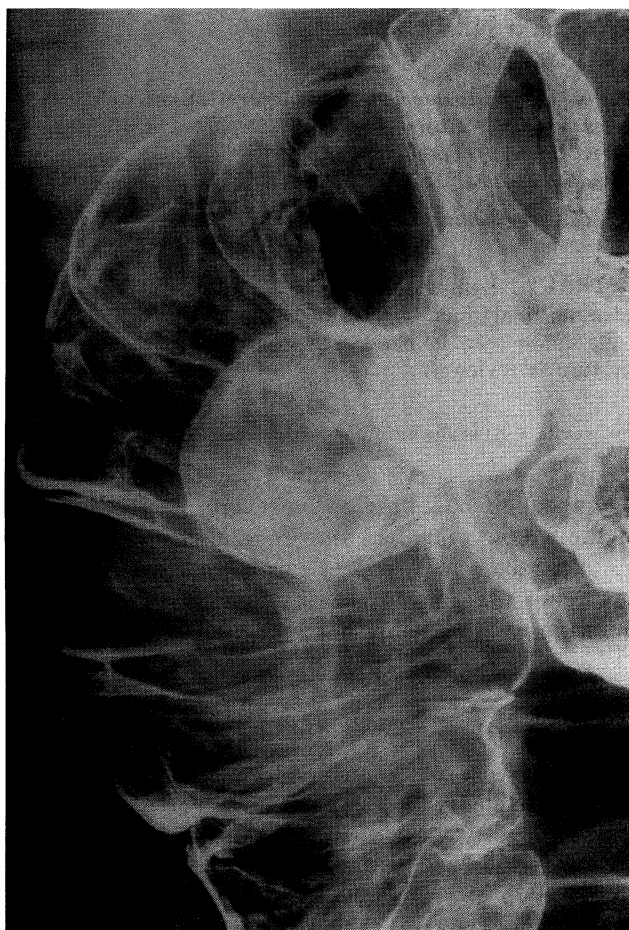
This double contrast roentgenogram shows a sharply defined, radiolucent, hemispheric mass in the hepatic flexure.
